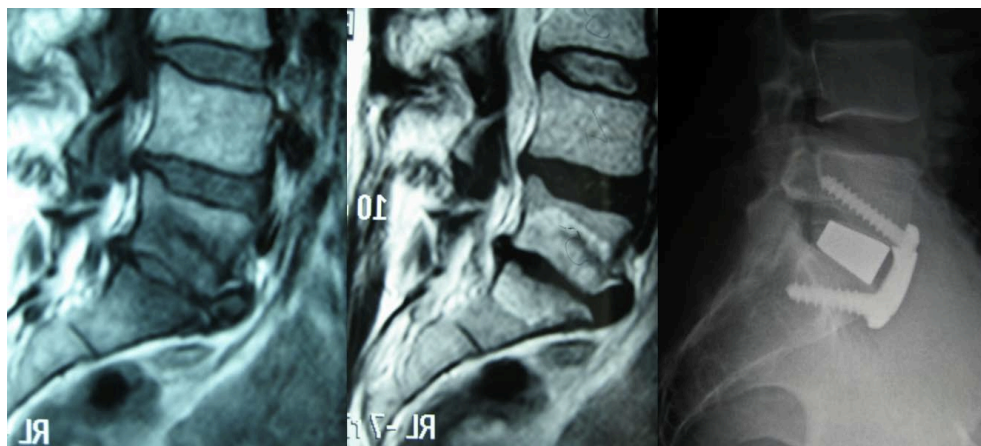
Preoperative sagittal lumbar MRI (T1 and T2 sequences) showing a L5-S1 discopathy (Pfirrmann 5) and postoperative X-ray (lateral view) of a L5-S1 ALIF. The patient has been treated with a tantalum cage and a three-screw anterior plate. This construct has the same stability than an anterior cage with four pedicle screws. It is clearly evaluable how the segmental lordosis have been properly increased after surgery.
